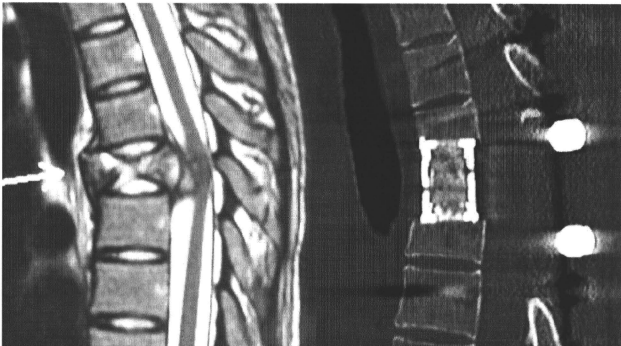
Case 3. Comparison of preoperative MR sagittal image (left) and postoperative (right) CT sagittal image. The images demonstrate the precise total *en bloc* spondylectomy from caudal T4 to cranial T6 by spinal osteotomy and reconstruction using a titanium mesh cage with an autogenous bone graft.
